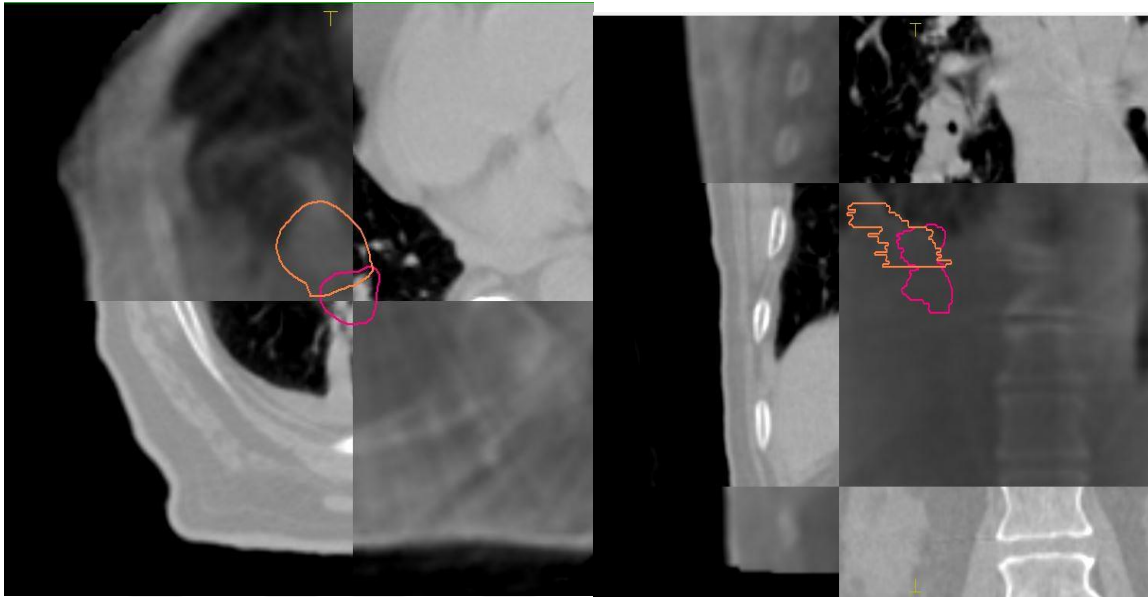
Delineation of GTV for a single fraction of 4DCBCT and ITV in 4DCT images, with using lung window level in a diaphragm lesion
